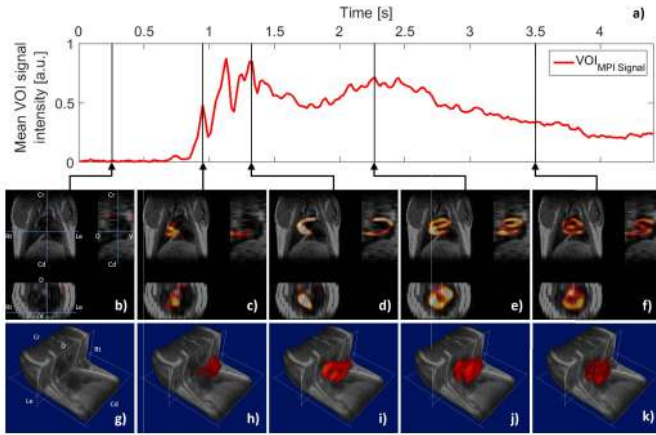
Hybrid dataset comprising the coronal 3D high-spatial resolution MSME MRI dataset (grayscale) and the 3D + t MPI dataset (redscale). (a) depicts the main bolus passage as spatio-mean MPI signal intensity over time (i.e. the Time-Intensity-Curve) of the reconstructed MPI repetitions (repetition 130 – 350, TR = 0.021 s). (b)-(f) show orthogonal views of the hybrid dataset for selected time points. (g)-(k) depict a volume rendered representation of the respective time-points. Videos of the orthogonal and volume rendered visualization are provided as supplementary material S1 and S2 to this manuscript.
